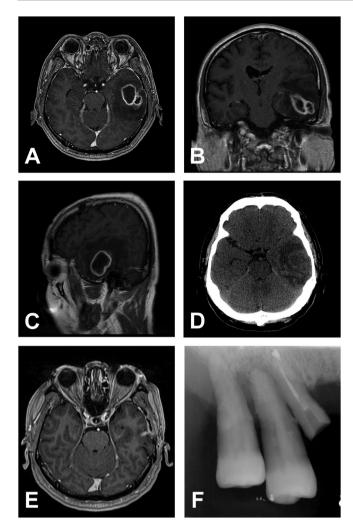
Magnetic resonance imaging (MRI) and computed tomography (CT) images and periapical radiograph of our patient. MRI T1 weighted axial (A), coronal (B) and sagittal (C) views with contrast showed a lobulated mass lesion measuring  $3.6\,\text{cm}\times2.6\,\text{cm}\,\text{at}$  the left temporal lobe with prominent subcortical edema and rim-enhancement. The MRI findings were compatible with an abscess or a metastatic lesion. (D) CT scan image showed a mass about 3.9 cm in greatest dimension at the left temporal lobe with evident perifocal edema, resulting in a mass effect. The CT scan finding was also compatible with an abscess or a metastatic lesion. (E) MRI image with contrast 6 months after surgery showed complete resolution of the brain abscess. (F) The periapical radiographs revealed that the teeth 13 was a retained root, teeth 14 and 15 had severe chronic periodontitis, and tooth 14 also had a periapical radiolucent lesion.
